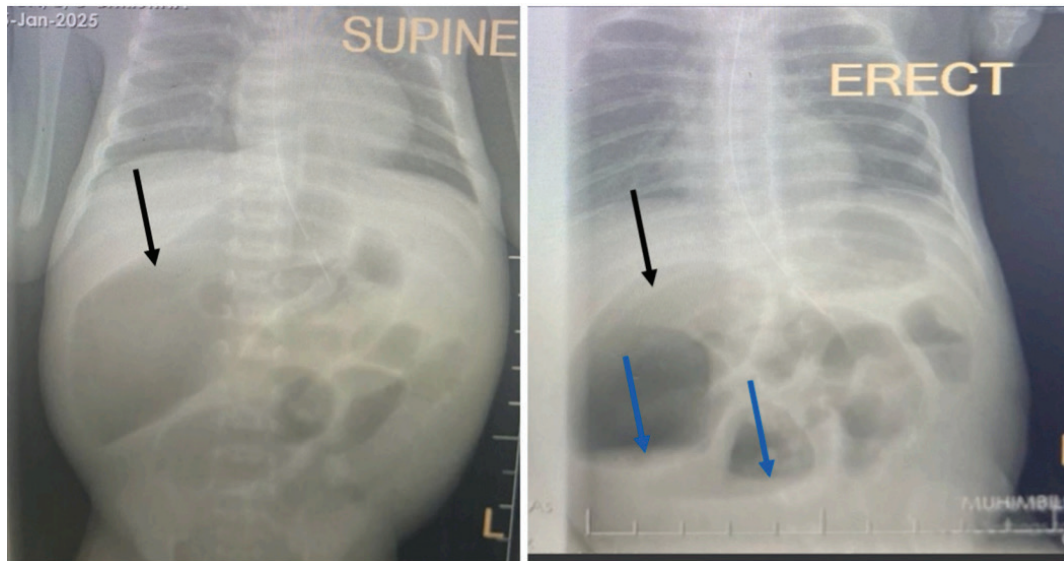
Supine and erect abdominal X-rays showing multiple air-fluid levels (blue arrows) and markedly dilated small-bowel loops (black arrows), consistent with a neonatal distal intestinal obstruction.
